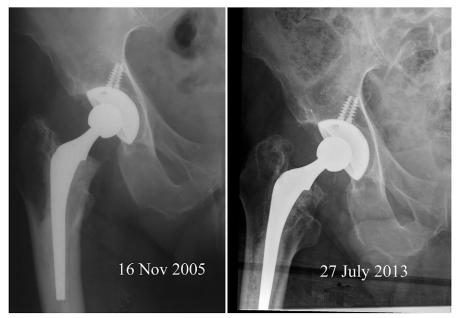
Radiographs made at 2.5 and 10 years after total hip arthroplasty with a Marathon liner was performed in a 71-year-old man. He required revision at 10.4 years because of pain. The stem had subsided, with multiple fractures of the cement mantle. The cup was well fixed. There was no osteolysis.
